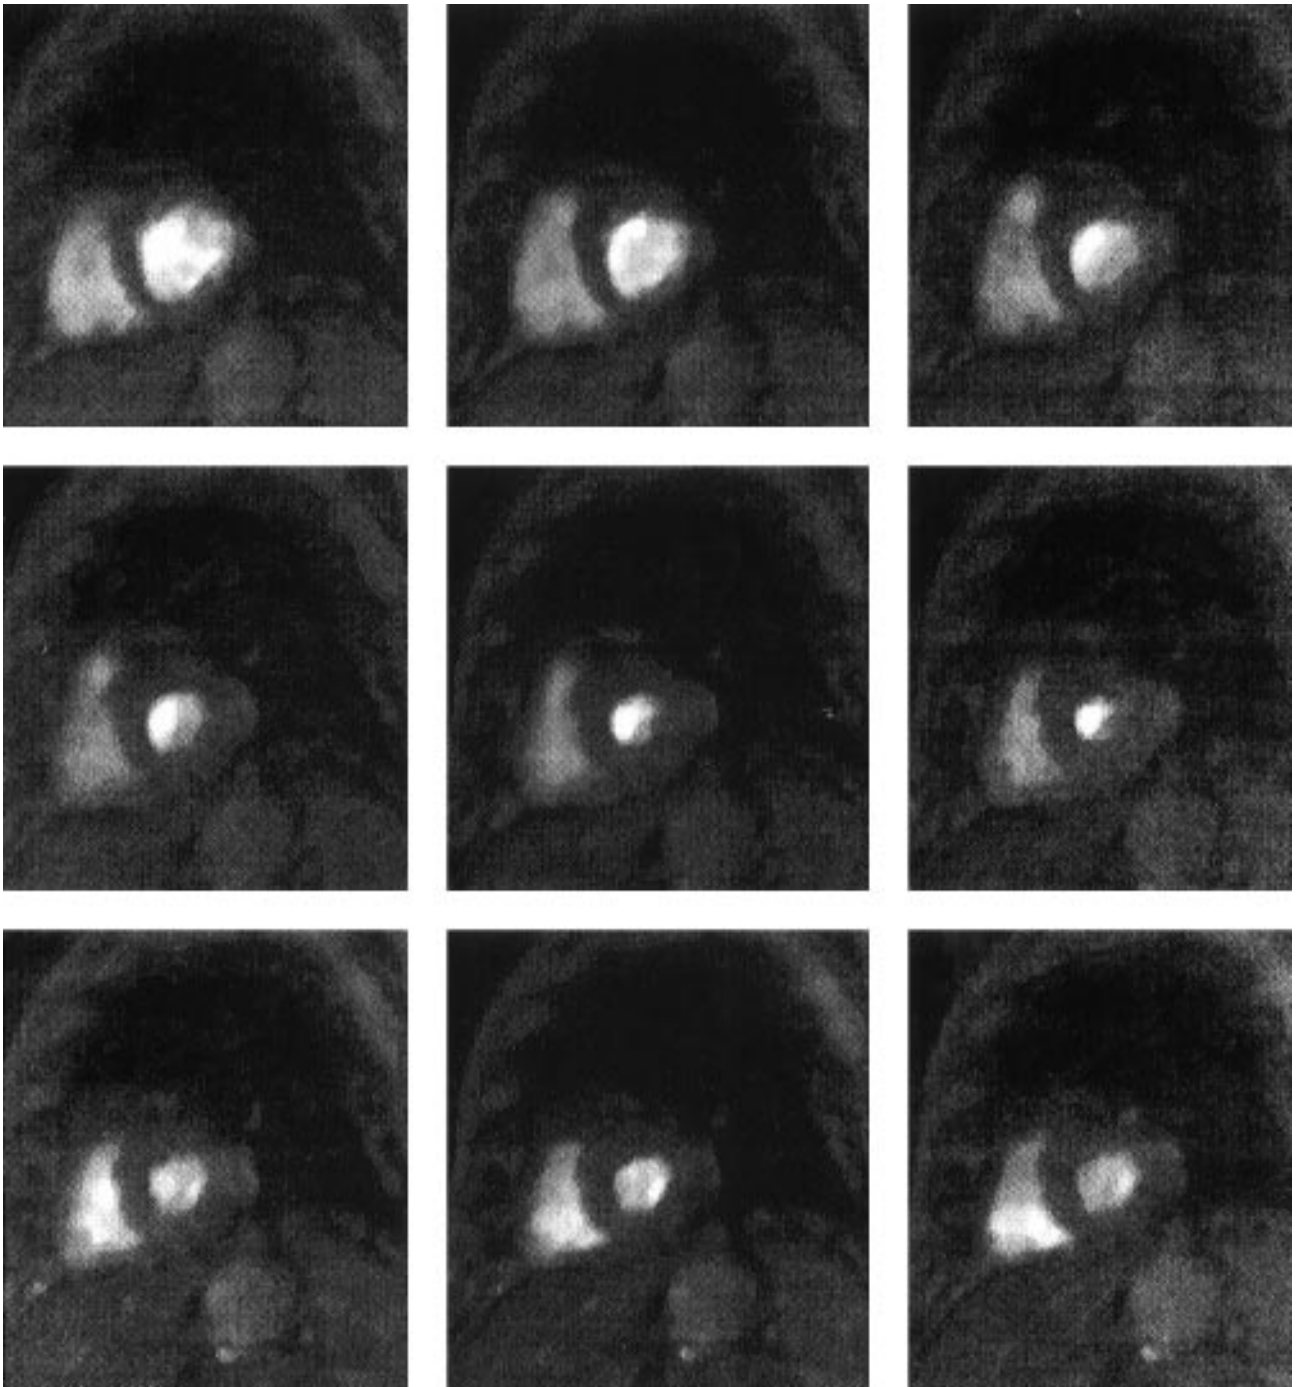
A sequence of nine filtered MR images taken throughout the cardiac cycle.
